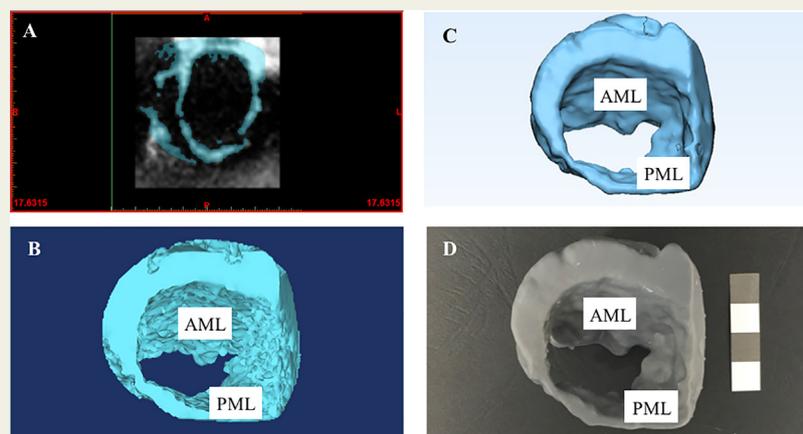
3D MV model produced from 3D echocardiography. Imaging data was segmented (A) and a virtual 3D model was calculated (B). The model was refined through anatomical engineering (C) and then 3D printed using stereolithography (D). Abbreviations: 3D, three dimensional; MV, mitral valve; AML, anterior mitral leaflet; PML, posterior mitral leaflet. [Note: calibration inset, 10 mm x 10 mm squares].
